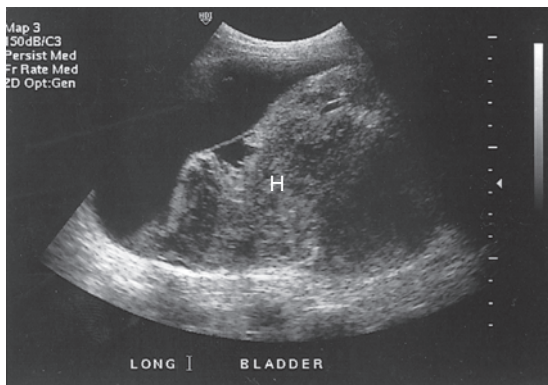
Bladder hematoma. A longitudinal sonogram in a patient with gross hematuria demonstrates a large hematoma seen as a complex mass (H) within the bladder. The hematoma almost completely fills the urinary bladder.
